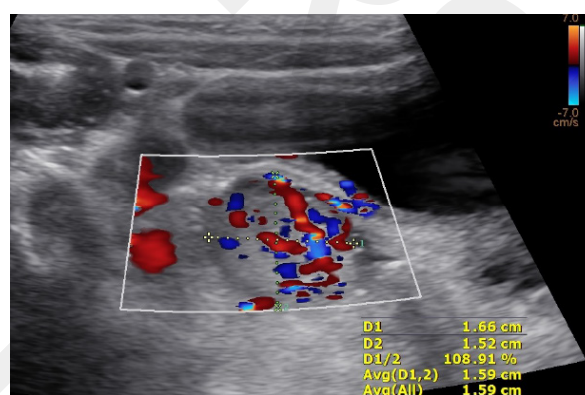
Patient No. 1. Abdominal ultrasonography revealed a well-vascularised, oval-shaped mass measuring 17 × 15 mm in the distal sigmoid colon
